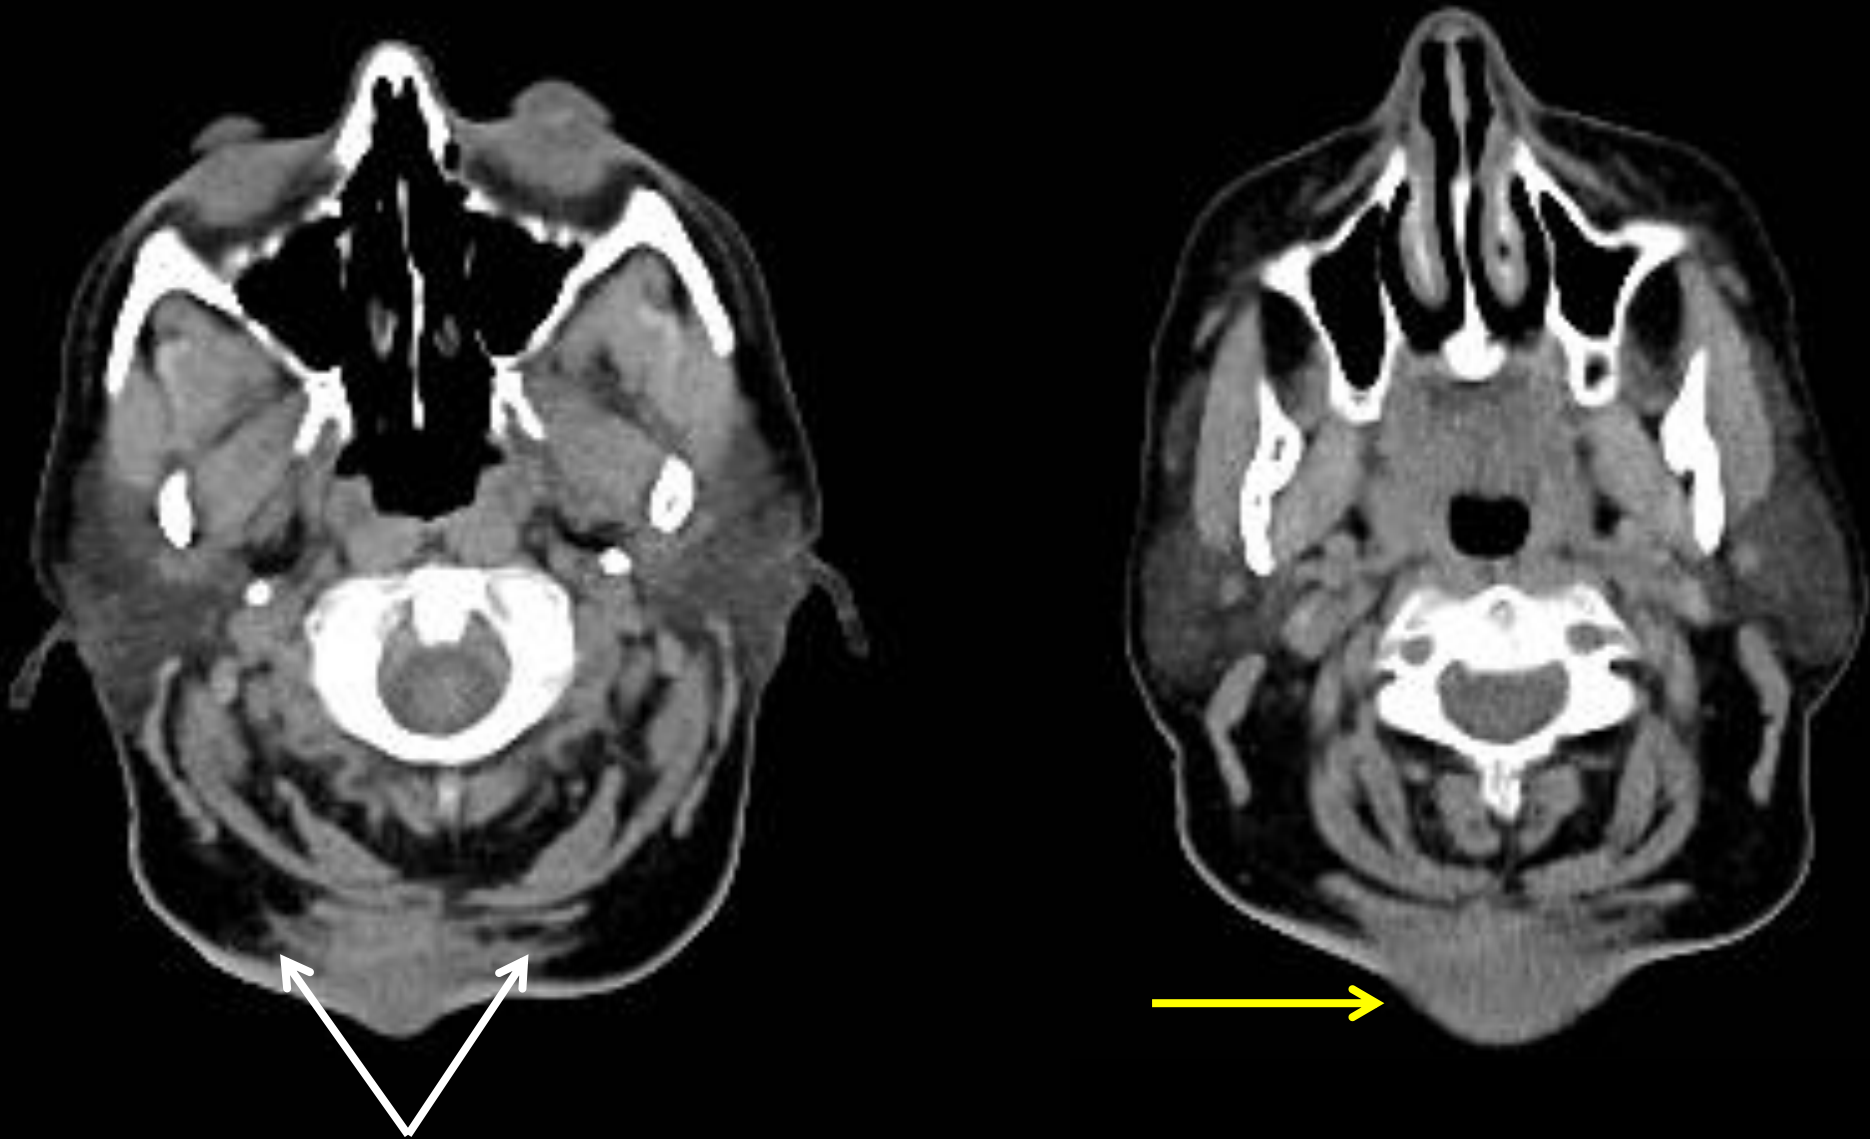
Axial CT images of cervical spine. Yellow arrow indicates 4 cm nodule. Fat stranding (white arrows) can be seen surrounding mass indicating inflammatory infiltration.
